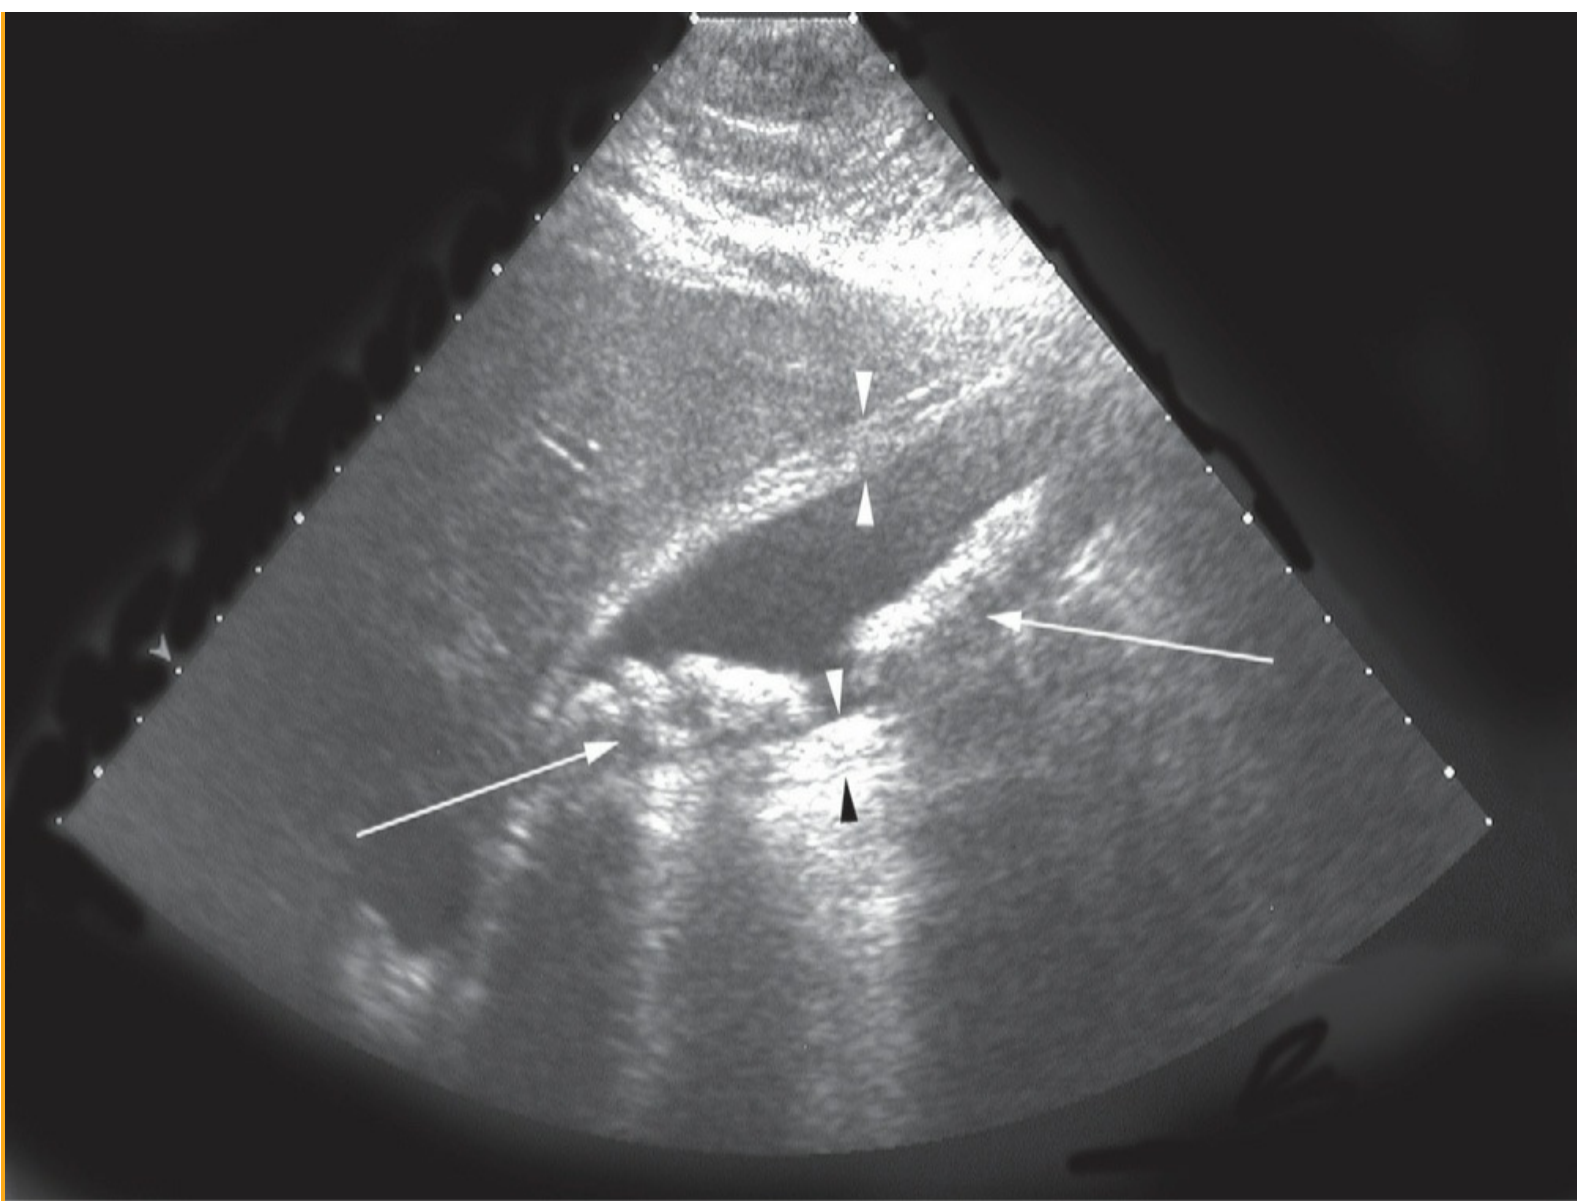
Ultrasonography from a patient with acute cholecystitis. The *arrowheads* indicate the thickened gallbladder wall. There are several stones in the gallbladder (*arrows*) throwing acoustic shadows. (Reproduced, with permission, from Brunicaardi F, Andersen DK, Billiar TR, et al, eds. *Schwartz's Principles of Surgery*. 9th ed. New York: McGraw-Hill; 2010.)
